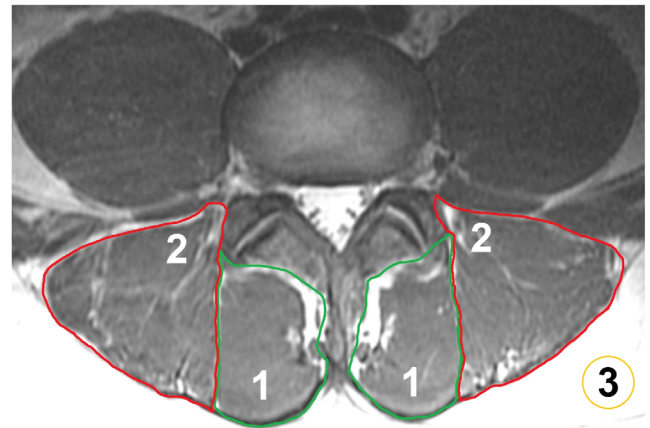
Segmentation of paraspinal musculature (PSM) and subcutaneous fat. Manual segmentations of the multifidus muscles (1) and erector spinae muscles (2) of both sides are shown at level L3/L4, together with a circular region of interest (ROI) placed in the subcutaneous fat (3). The segmentations of the multifidus and erector spinae muscles were used for the extraction of the level-wise fat fraction (FF) and muscle volume of PSM (based on the axial slices of an iterative decomposition of water and fat with echo asymmetry and least-squares estimation [IDEAL] sequence). Furthermore, segmentations of these muscles together with the ROIs in subcutaneous fat were used to calculate the muscle-fat index (MFI) as the mean signal intensity (SI) of PSM divided by the mean SI of homogenous subcutaneous fat (based on the axial slices of a T1-weighted fast spin-echo [FSE] sequence).
